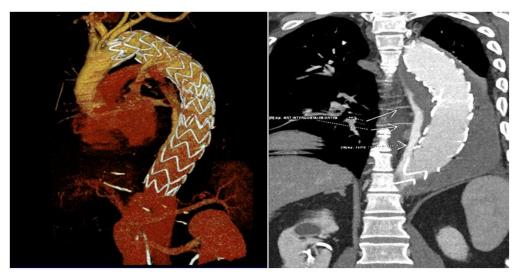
CT angiogram showing the stent covering the descending aorta from the left subclavian artery to 4 cm prior to the celiac trunk
